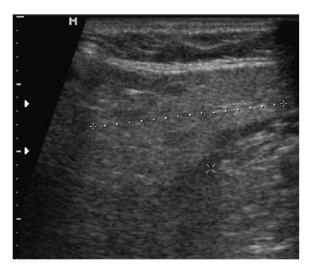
Ultrasound image showing mediolateral width.
